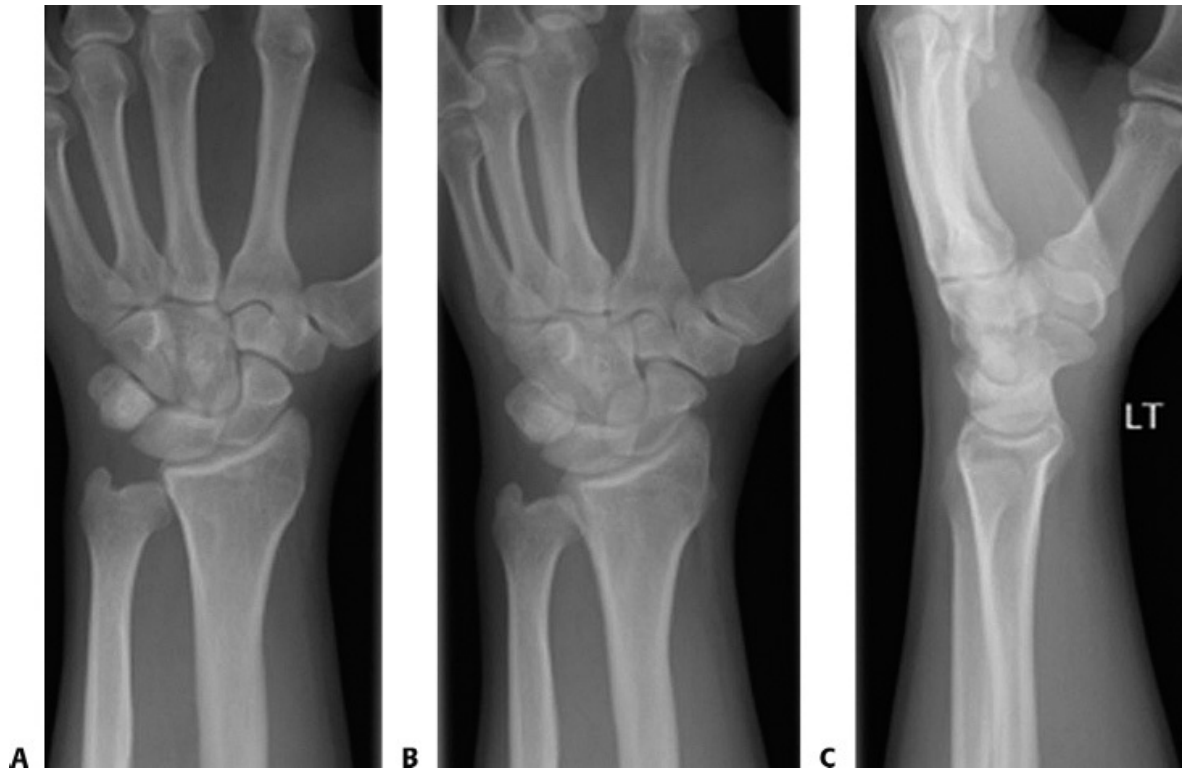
• PA, oblique, and lateral radiographs of a patient with a lunotriquetral injury. There is no apparent widening of the lunotriquetral interval or VISI deformity seen here; however, a lunotriquetral ligament tear was found on wrist arthroscopy after the patient failed nonoperative management.
